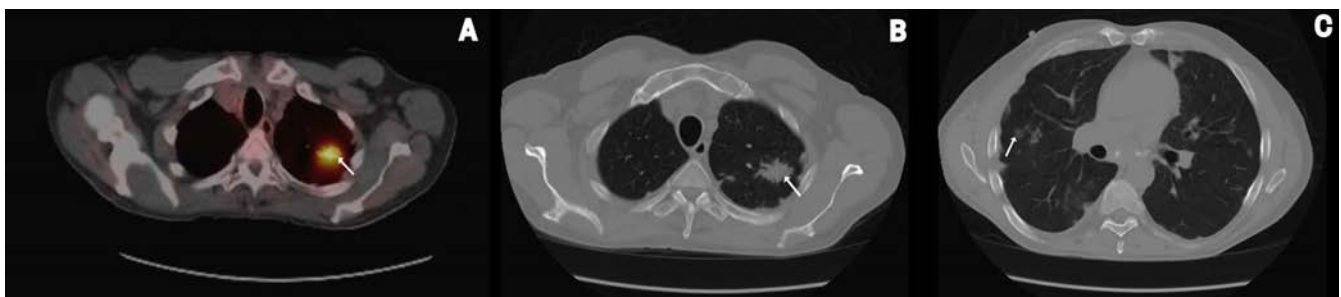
A and B, Interval development of a 3-cm left upper lobe consolidation in positron emission tomography scan (arrow in A) and computed tomography (CT) of the chest (arrow in B). C, Subcentimeter pulmonary nodularity in the right lung on CT of the chest (arrow).
